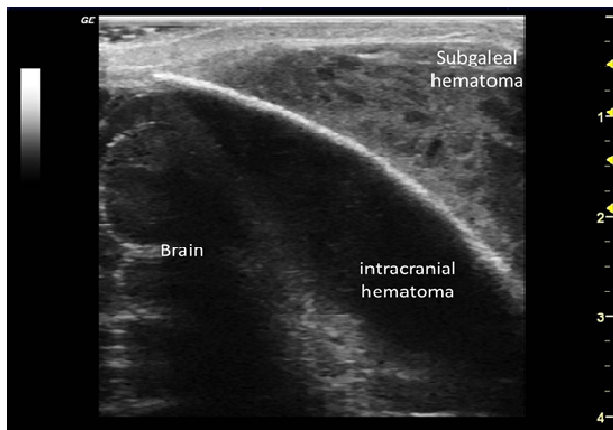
Image of ultrasound using 7 - 12 MHz linear probe. Identifies clearly the subgaleal and intracranial hematomas.
